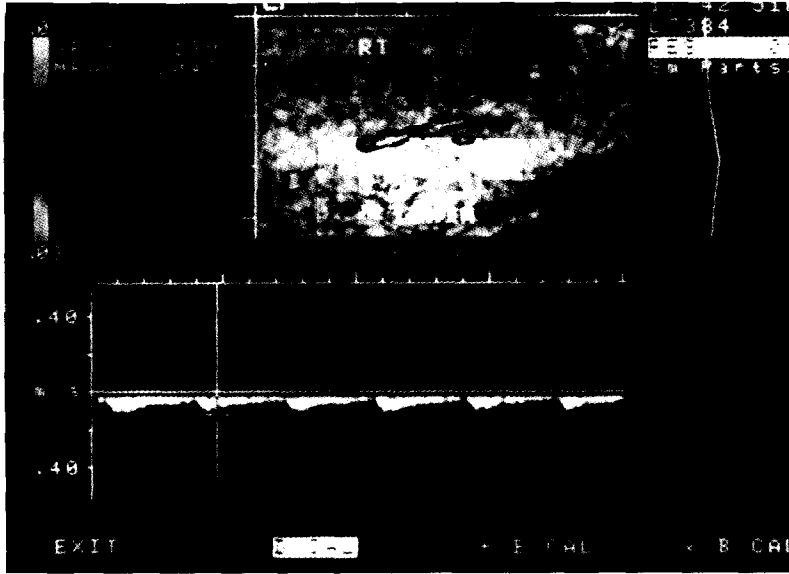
Colour doppler imaging of the right cavernosal artery. Systolic peak flow is 12 cm/sec. 15 minutes after injection. A case of arteriogenic impotence.
